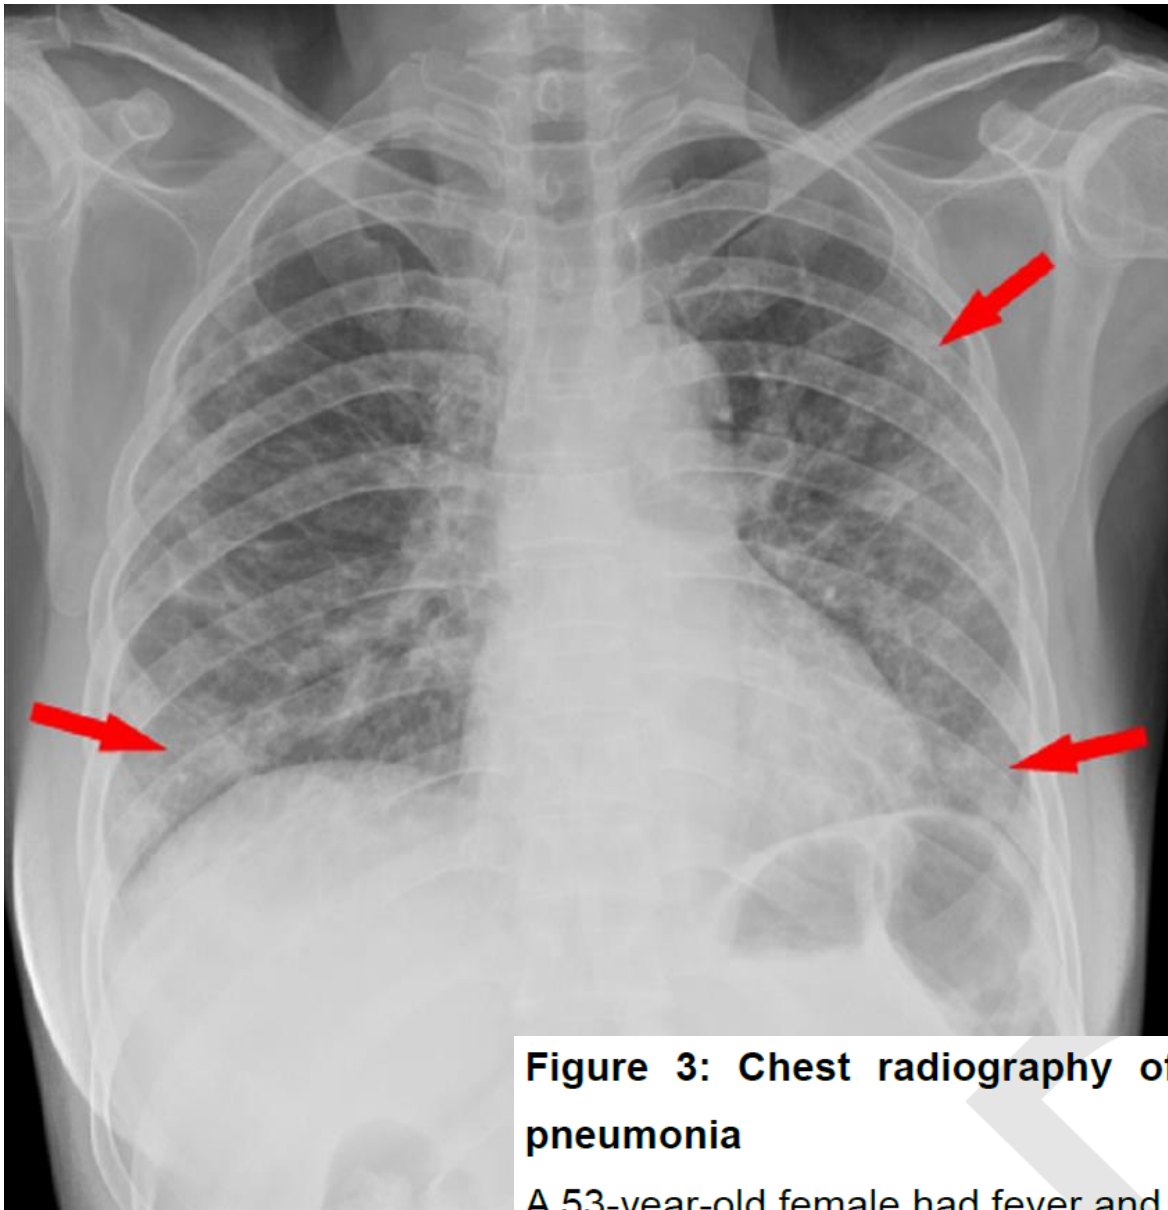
Chest radiography of confirmed Coronavirus Disease 2019 (COVID-19) pneumonia
